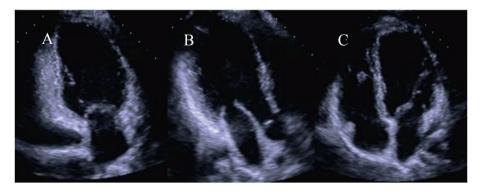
Two-dimensional echocardiographic images showing two-, three-, and four-chamber views (A–C, respectively).
